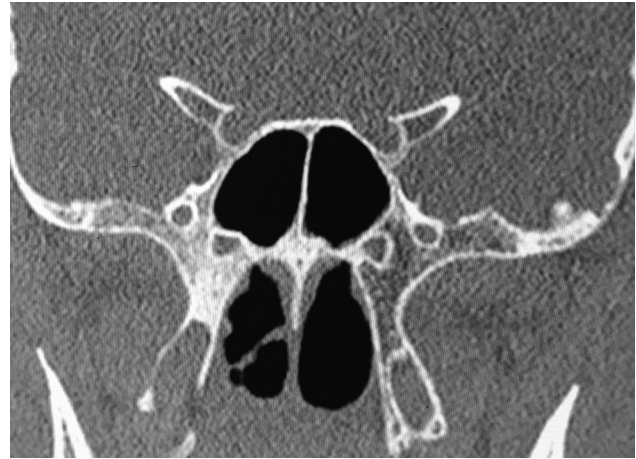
Coronal CT image of a 44-year-old male showing type I Delano's classification of optic nerve relation to the sphenoid sinus.
